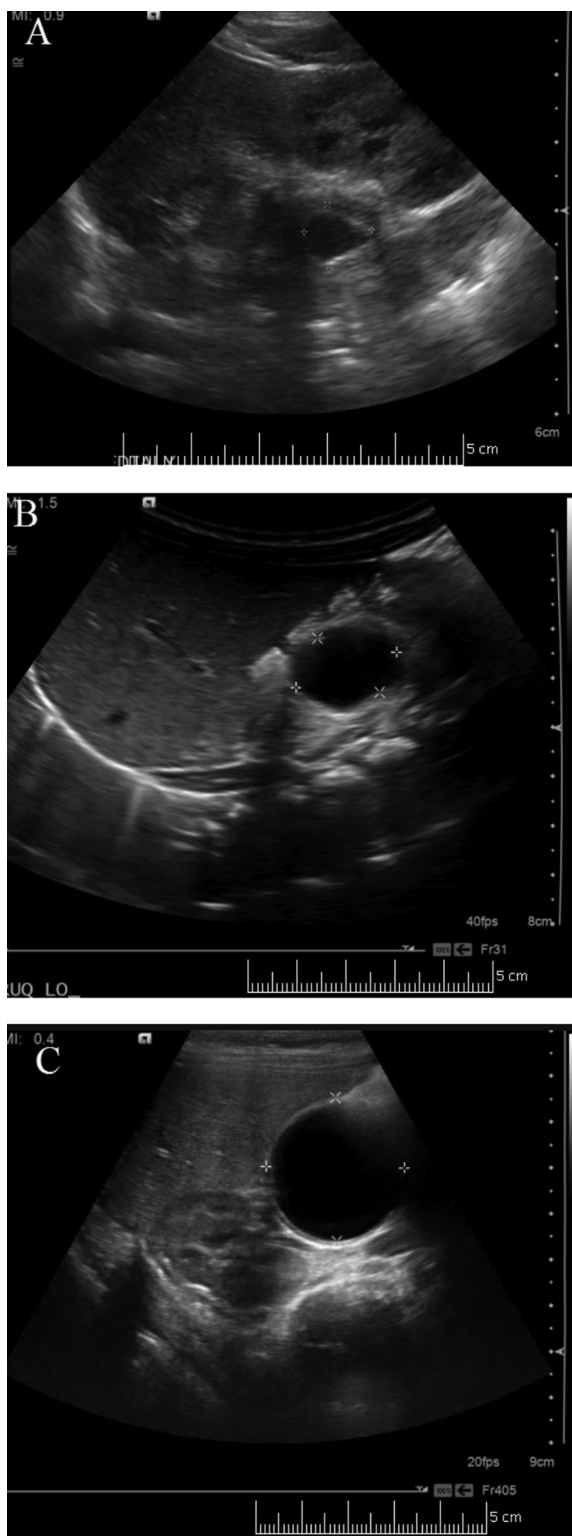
Serial abdominal ultrasound examination revealed a RUQ cyst with an echogenic wall that demonstrated increase in size over 6 mo.
